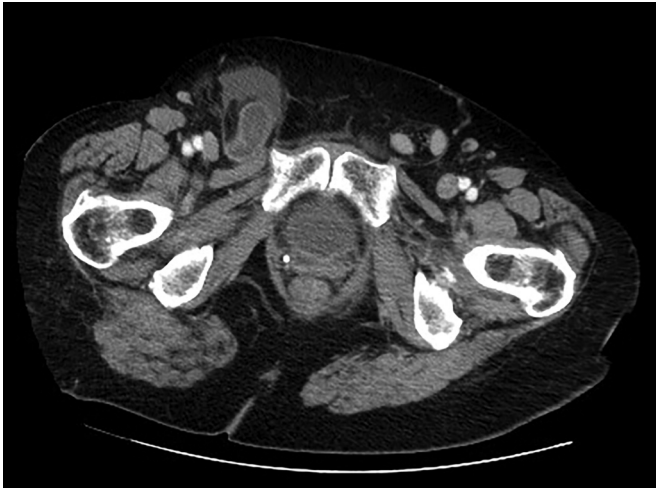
Computed Tomography scan demonstrating incarcerated femoral hernia containing small intestines.
